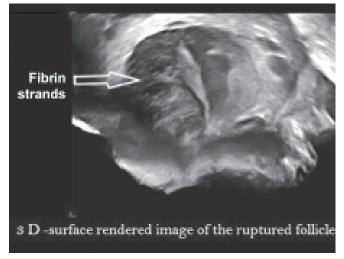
Three-dimensional ultrasound of an early corpus luteum
